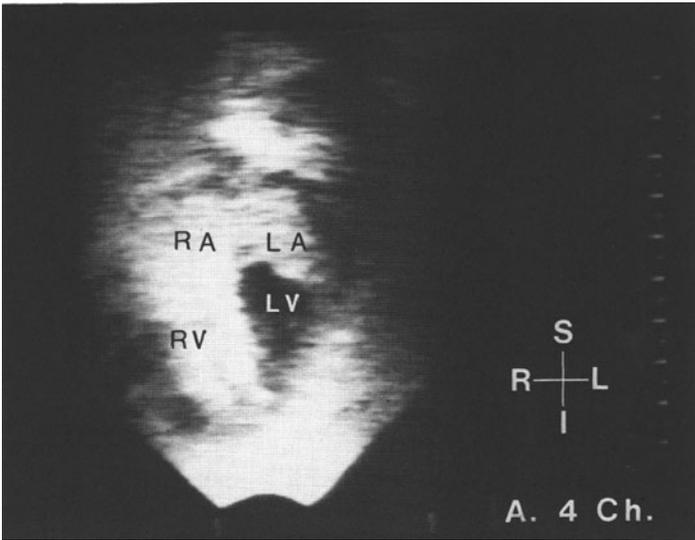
The top frame shows an apical four-chamber view of a patient with a secundum atrial septal defect after venous injection of contrast medium, as explained in the text. The left atrium was opacified, indicating the right-to-left shunt (abbreviations: *I*, inferior; *L*, left; *LA*, left atrium; *LV*, left ventricle; *R*, right; *RA*, right atrium; *RV*, right ventricle; and *S*, superior). The bottom frame shows a subcostal four-chamber view of a different patient, showing a diastolic negative jet of contrast representing left-to-right shunting through the atrial septal defect (black arrows).
